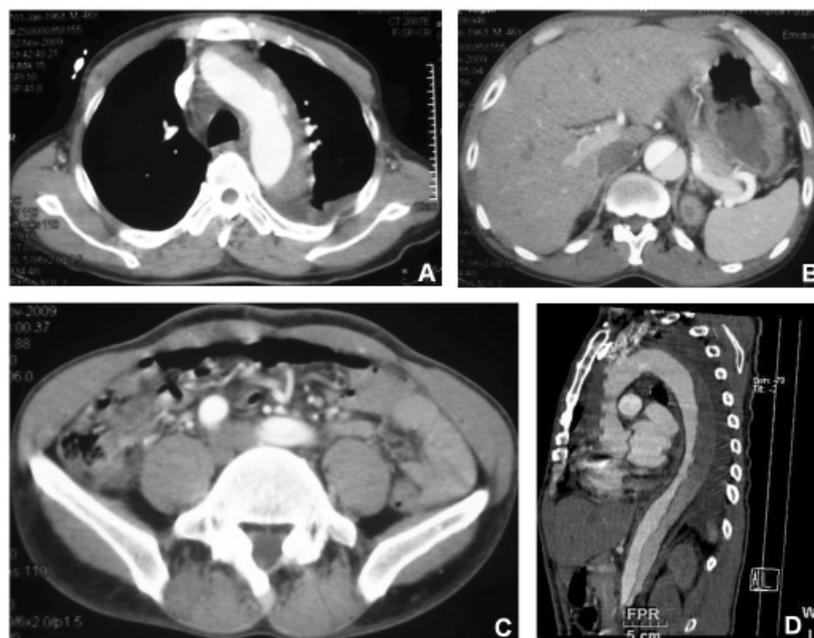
CT scan performed on November 2nd 2009 showing a type I aortic dissection beginning in the ascending aorta and extending to the left iliac artery (A, B, C, and D).
